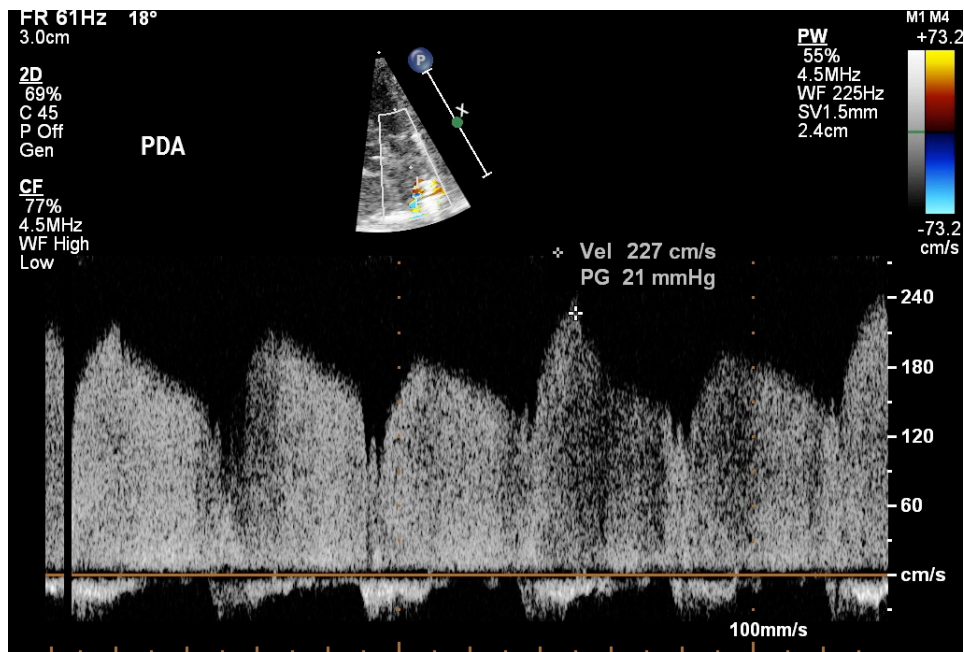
Continuous wave Doppler used to measure the blood flow velocity through the patent ductus arteriosus. The marker represents the peak velocity of flow in the PDA.
